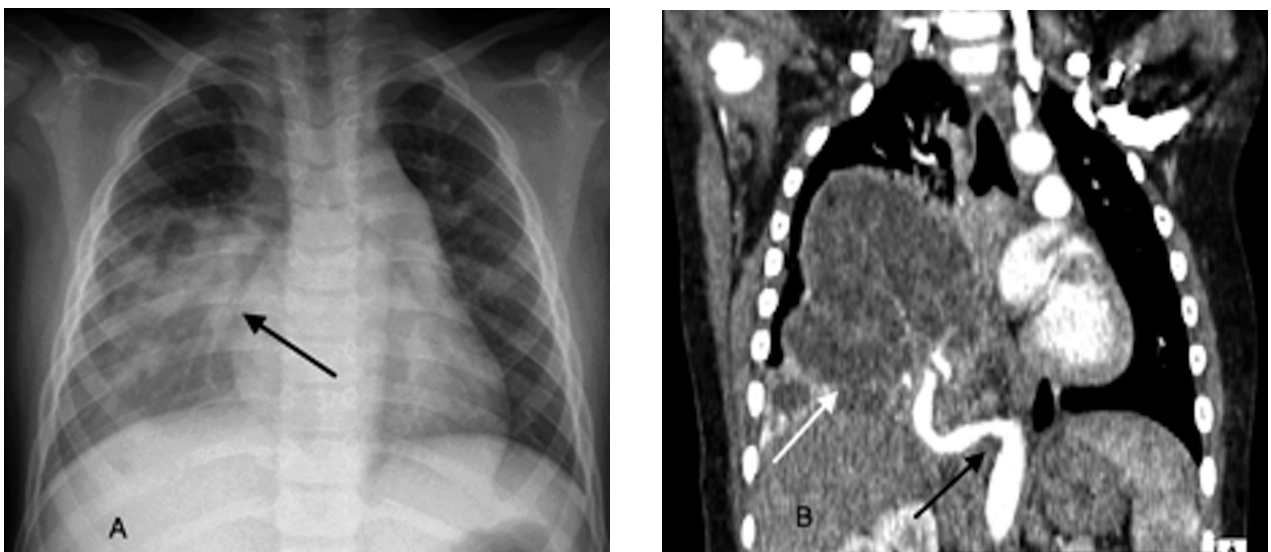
(A) XR shows parenchymal densification in the middle and lower right lung field. (B) CT displays a complex expansive formation characterized by multiple septa taking contrast (white arrow), associated to a dorso-basal area of pulmonary consolidation replenished by an abnormal blood vessel originating from the aorta near the thoraco-abdominal transition (black arrow)
